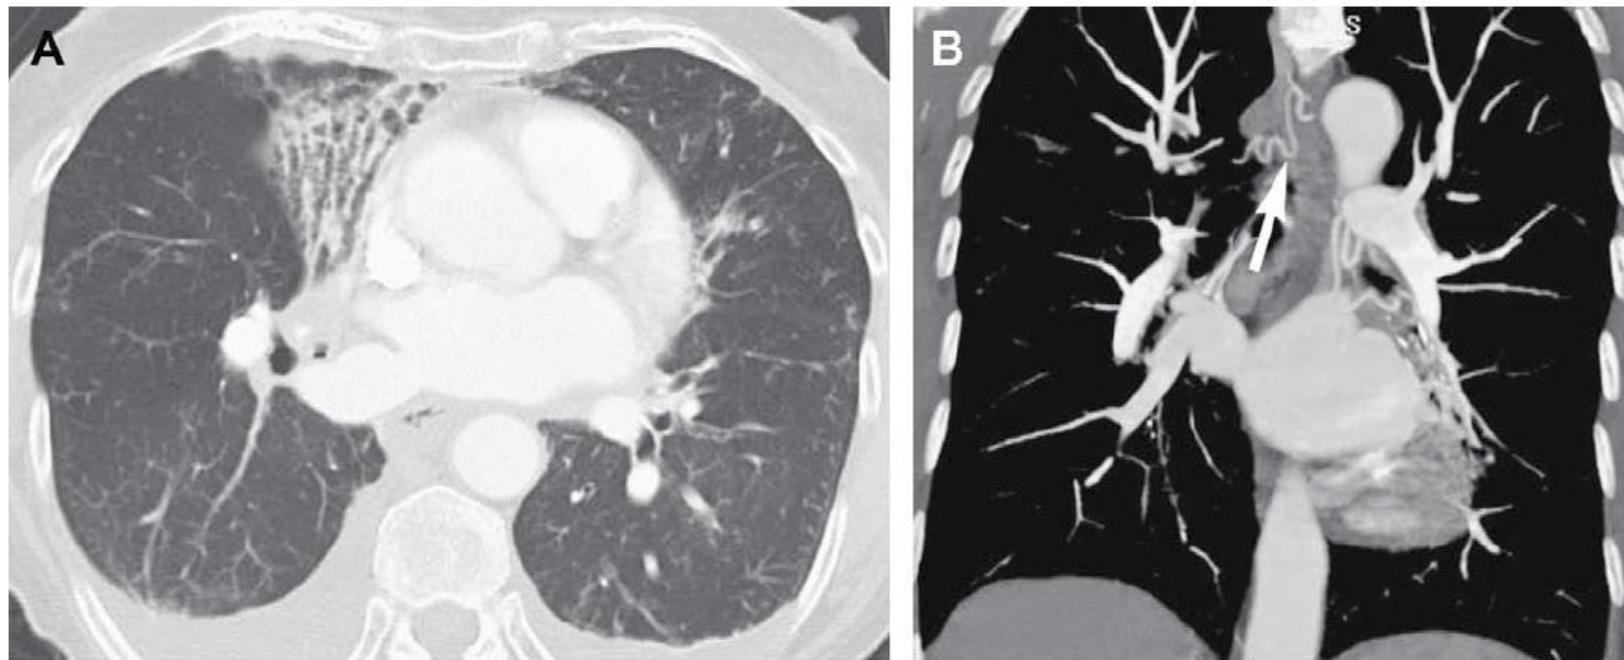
Bronchial artery collateral formation in bronchiectasis: a 76-year-old woman with chronic productive cough has new-onset of severe, recurrent hemoptysis. CT of chest with intravenous contrast shows severe bronchiectasis and scarring of the right middle lobe (A). The dilated bronchial arteries (white arrow) providing collateral flow to the lungs are better demonstrated on the coronal thin-MIP (6 mm) reformatted image (B).
